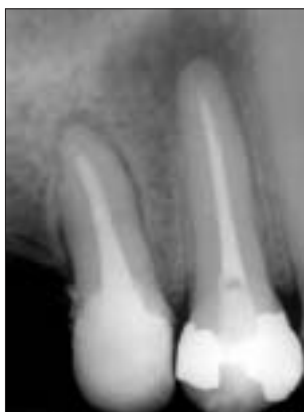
Outcome classification as “healed” vs. “healing.” Immediate post-operative radiograph of maxillary first and second premolars with apical periodontitis.
